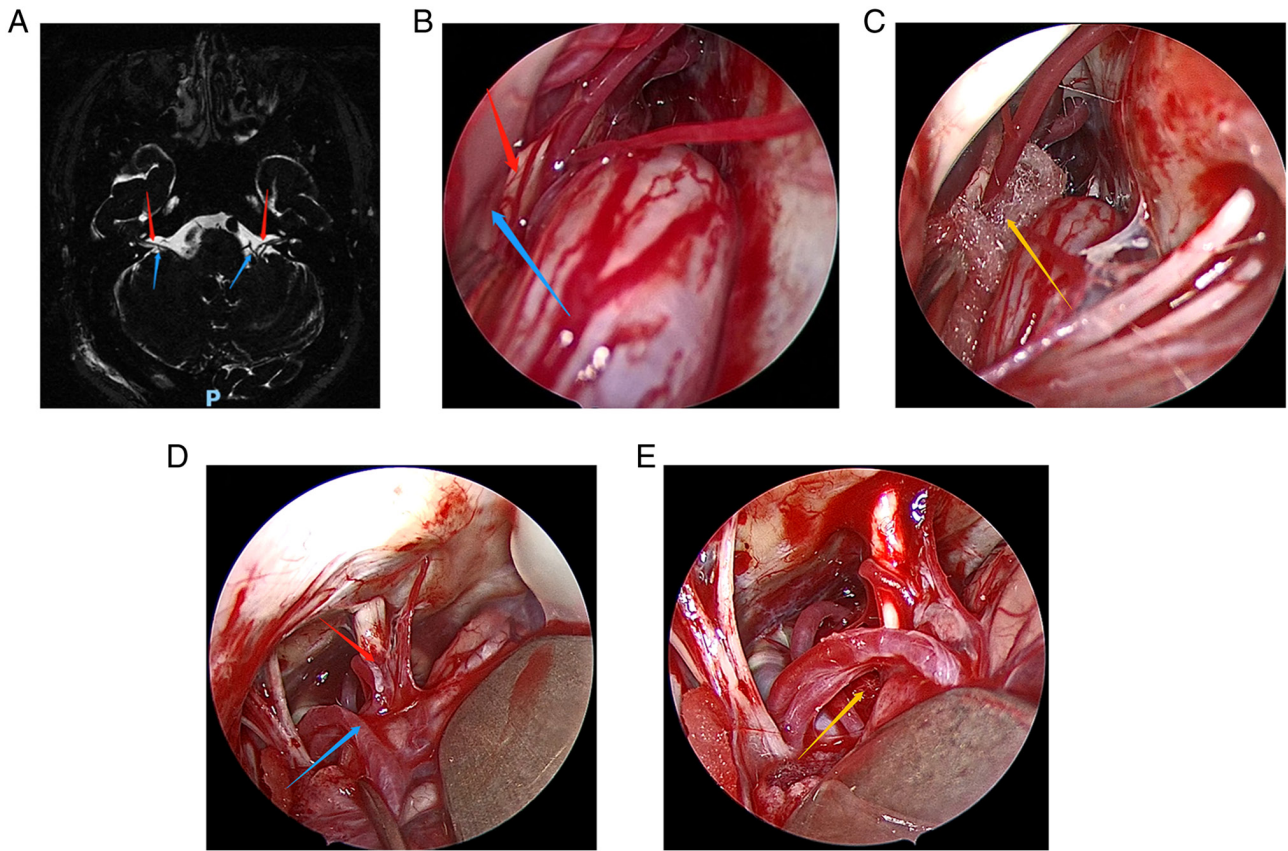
Patient 3. (A) Preoperative head magnetic resonance imaging of the patient. (B) In the first operation, the anterior inferior cerebellar artery and compressed cranial nerves were clearly visible under the endoscopic view. (C) The Teflon pad was placed between the root exit zone of cranial nerve 7 and the anterior inferior cerebellar artery under the endoscopic view in the first operation. (D and E) They are the images observed under the endoscope during the second operation, the offending blood vessel is the small artery. Red arrows indicate the compressed cranial nerve vessels, blue arrows indicate the offending blood vessels and yellow arrows indicate the Teflon pad.
